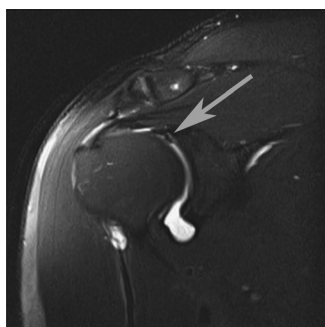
Coronal oblique MRI image from an arthrogram demonstrates a superior labral tear (SLAP) (*arrow*).
